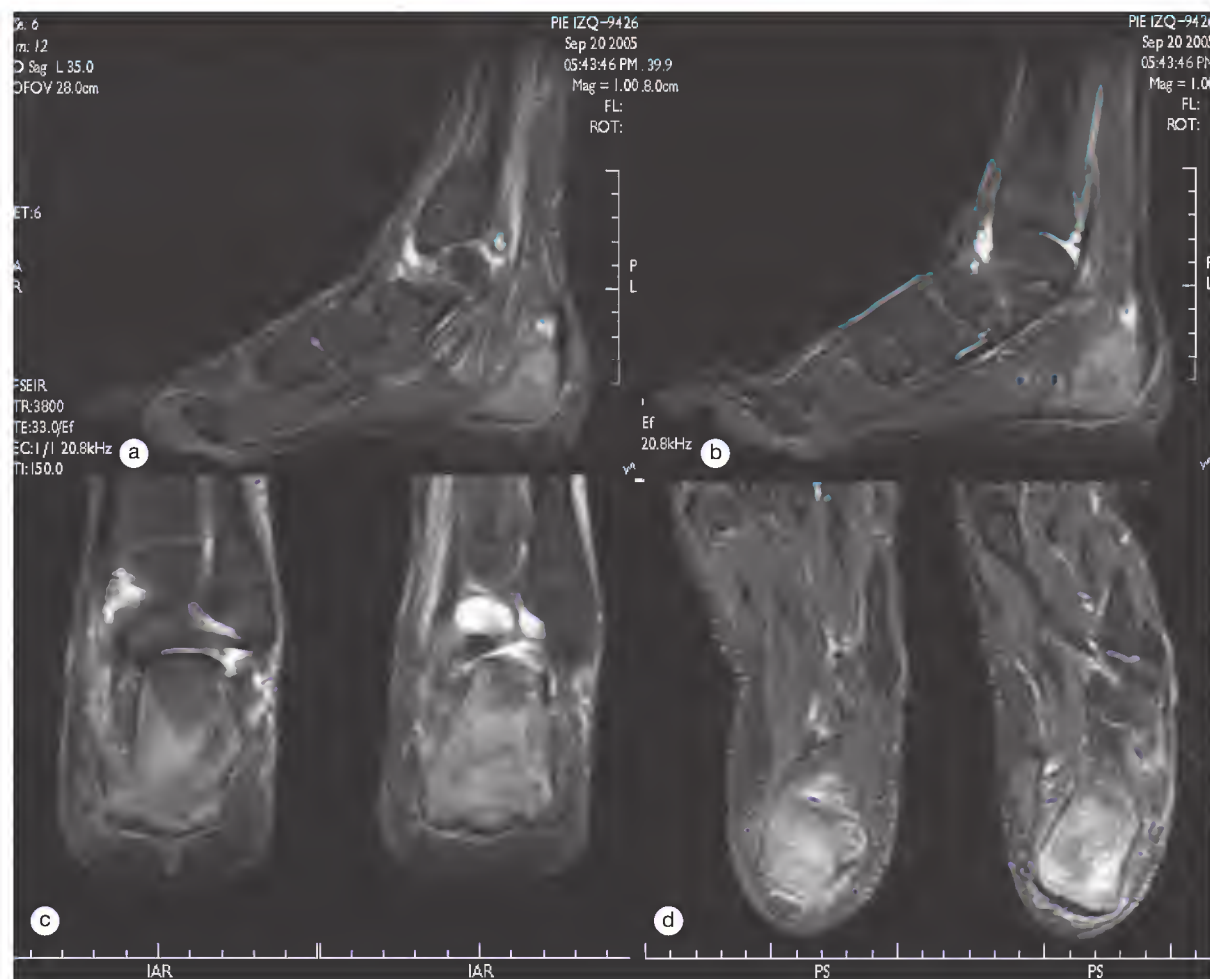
T2-weighted fat-suppressed magnetic resonance images of the foot of a 15-year-old boy with ankle swelling and a painful heel (Achilles tendon and plantar fascia) for approximately 6 months. (a and b) Sagittal-lateral views showing synovial fluid effusion in the posterior and anterior ankle joints, the retrocalcaneal bursae, and possibly the fat as well as bone edema of the calcaneus, including the attachments of the Achilles tendon and its continuation to the plantar fascia. (c) Synovial fluid effusion of the ankle joint, edema around the posterior peroneal tendon and extensive edema of the calcaneus on sagittal-posterior views. (d) Coronal views showing extension of the edema to the calcaneus.
